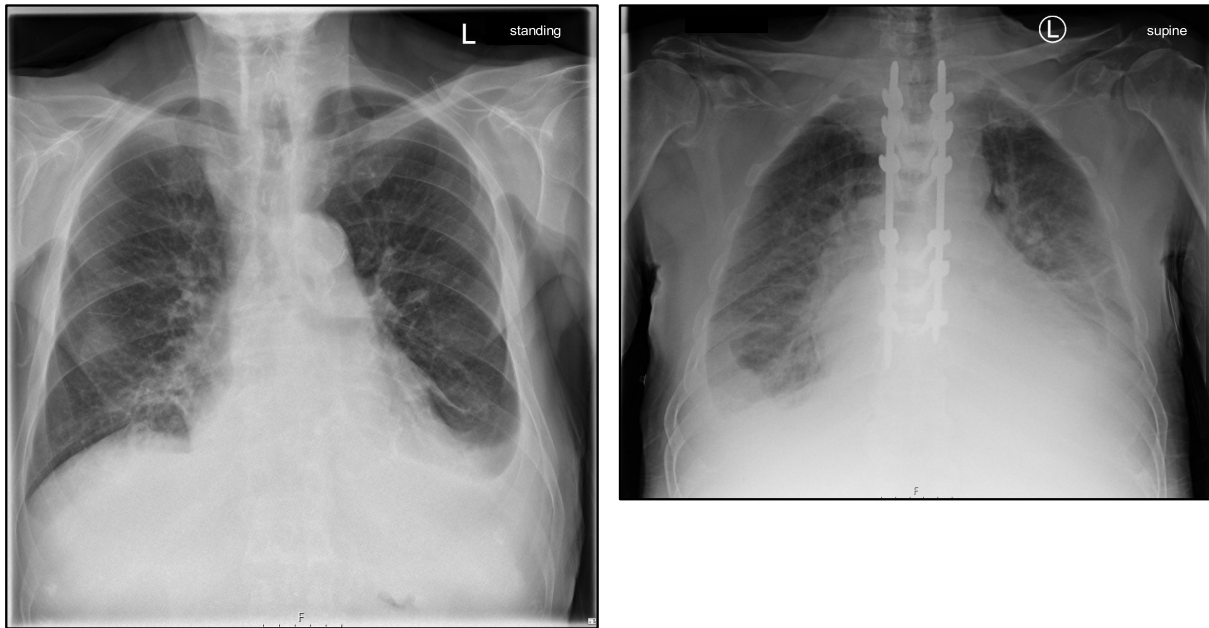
Cardiac decompensation resulting in pleural effusion (chest X-ray on the left side) and pulmonary edema (chest X-ray on the right side) in patients with severe aortic stenosis.
